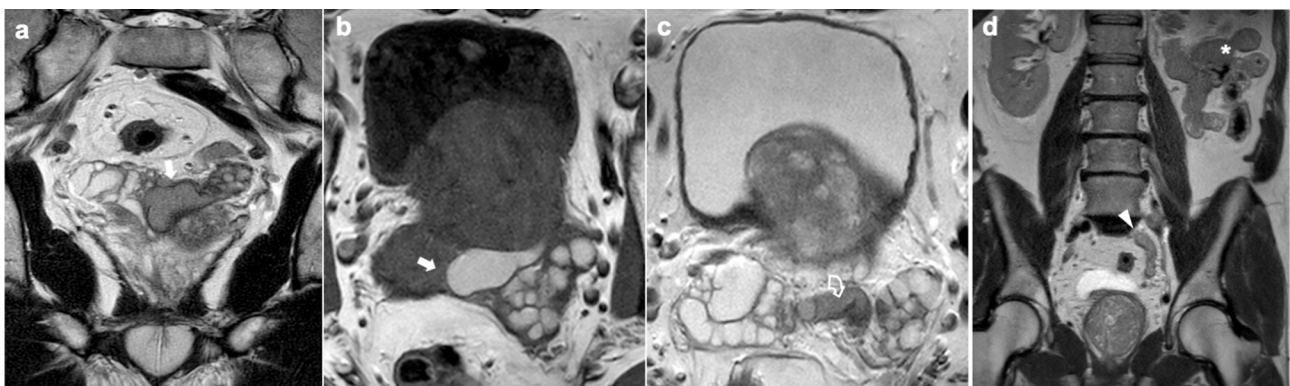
Coronal T2w (a) and axial T1w images (b) show a left unilateral cyst of the seminal vesicle with protein content (arrows), while axial T2w image (c) depicts ectasia of the left vas deferens with inhomogeneous content (curved arrow). Coronal large FOV T2w image (d) of the same patient shows ipsilateral renal agenesis (asterisk) and the ureteral embryonic residual (arrowhead). The findings are consistent with Zinner syndrome. T2w T2-weighted, T1w T1-weighted, FOV field of view.
